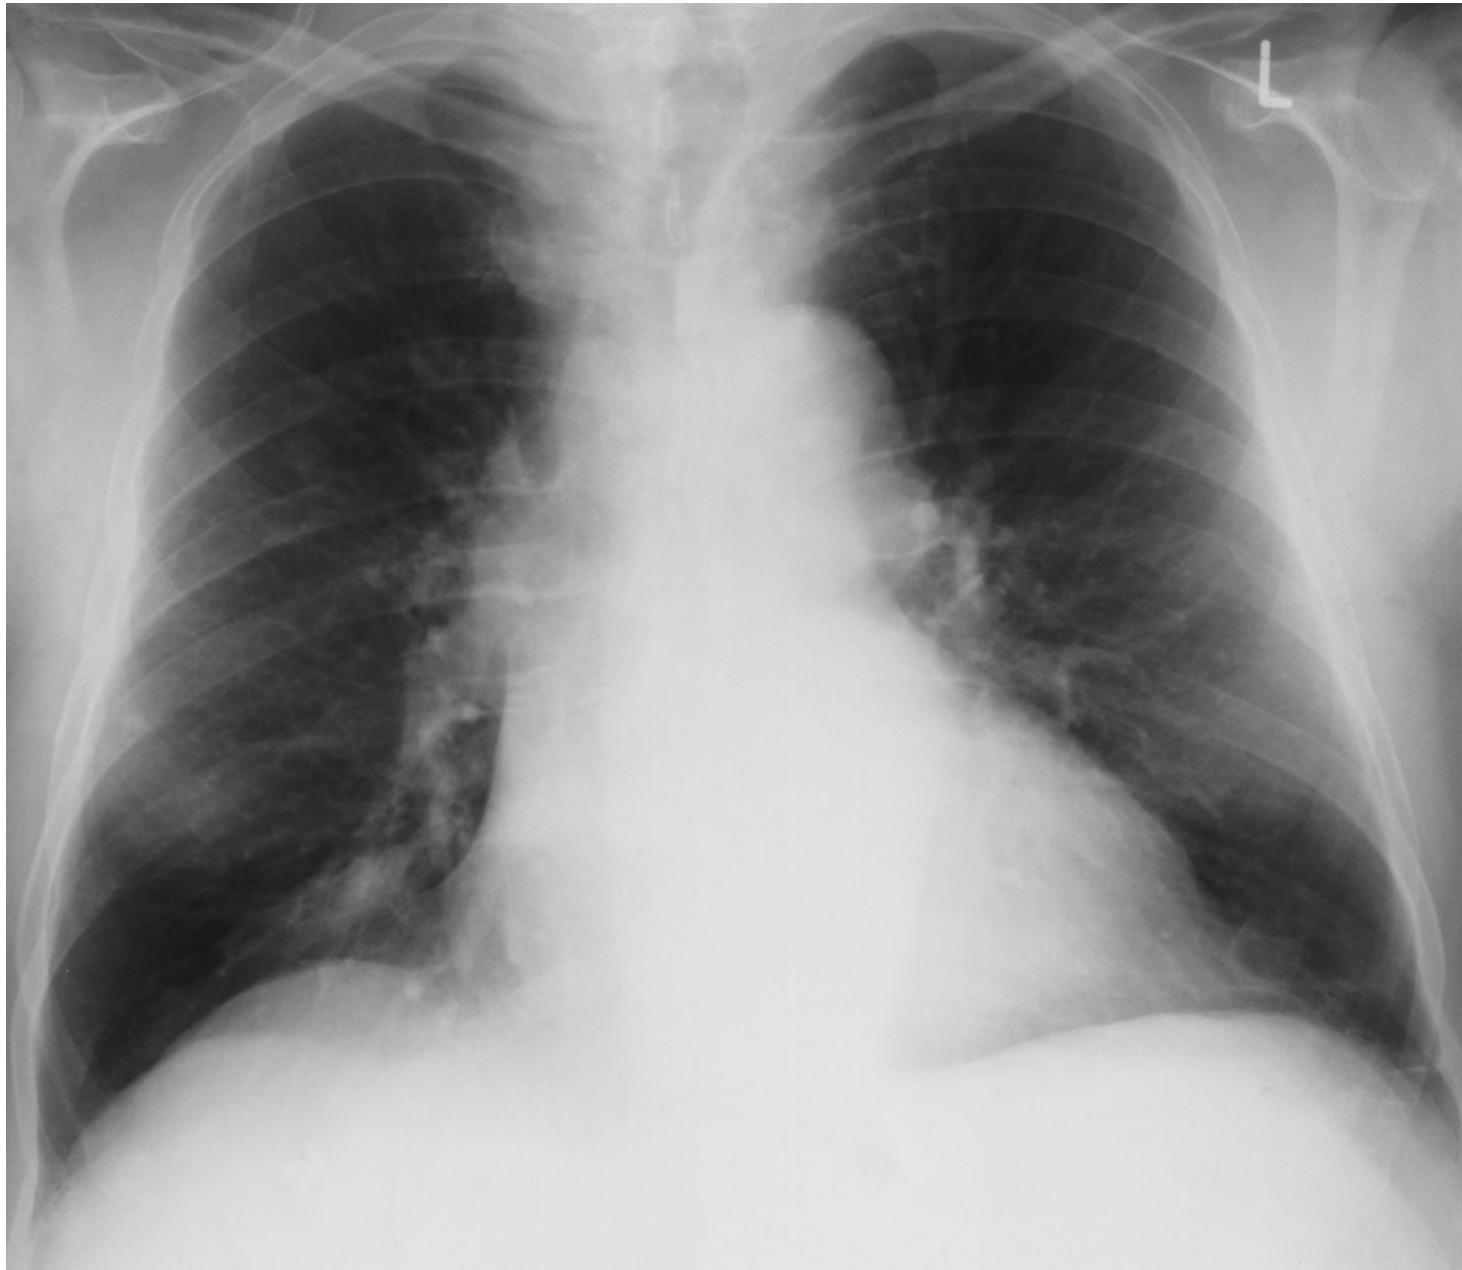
Routine chest radiograph in a male chronic smoker prior to cardiac catheterization.
